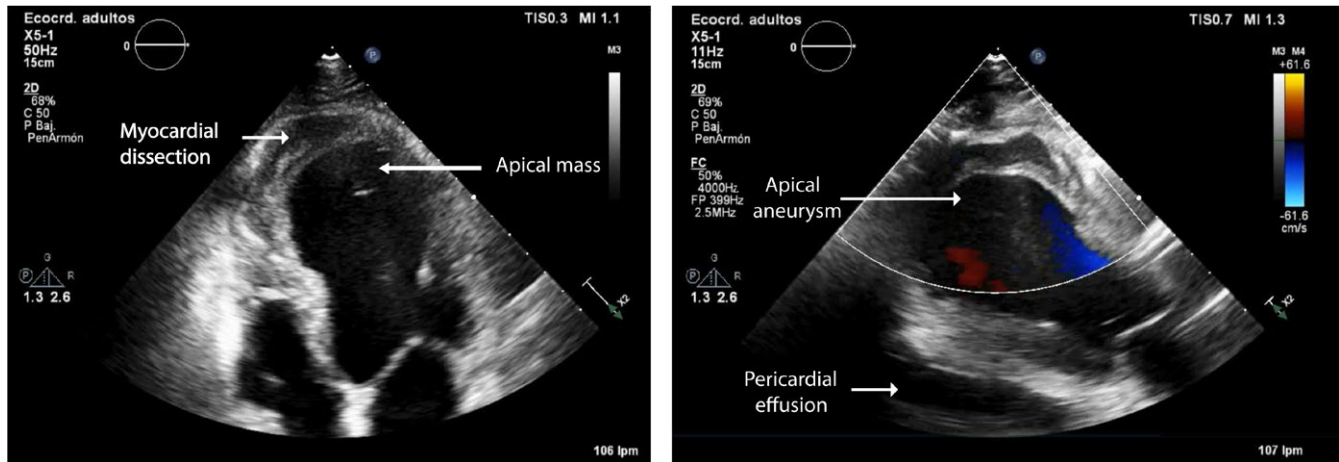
Two-dimensional transthoracic echocardiogram (2DTTE) and color Doppler showing a severely dilated left ventricle with an apical aneurysm and a severely deteriorated systolic function with moderate pericardial effusion. A closer inspection revealed an apical intracavitary echogenic mass and myocardial dissection
